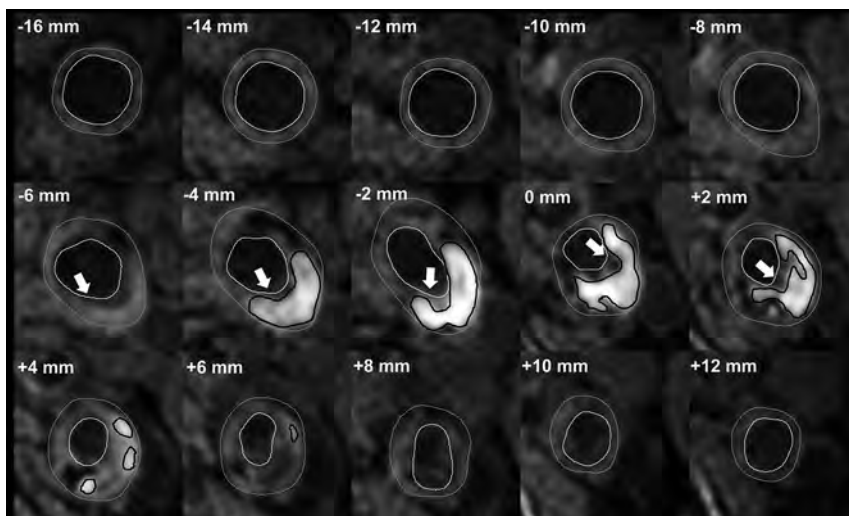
A patient's dataset acquired with an inversion recovery turbo field echo sequence. Delineation of the inner and outer vessel walls and IPH in every 2-mm-thick MR imaging section proximal and distal to the section with the narrowest lumen (0 mm). Gray outline = outer vessel wall, white outline = inner vessel wall, black outline = IPH, white arrow (−6 mm to +2 mm) = MR imaging slices in which the FC status is scored as thin or ruptured. The status of the FC was determined by using the postcontrast T1-weighted QIR TSE sequence. There is a larger volume of IPH at the proximal side of the section with the narrowest lumen (0 mm), and most of the slices with a TRFC cap are also located at the proximal side.
